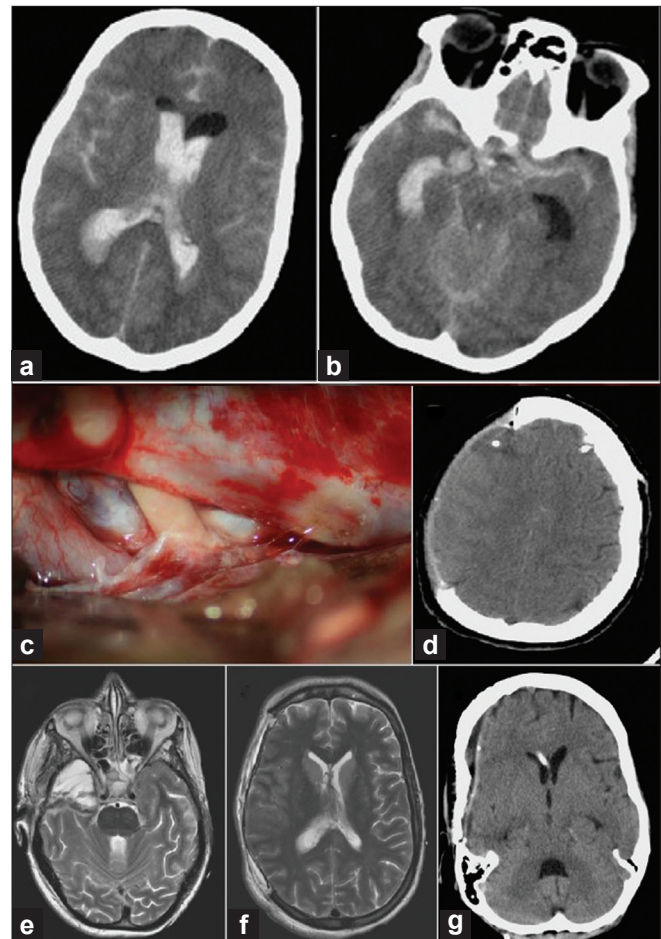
(a–b) Axial CT images demonstrating acute SAH and IVH from a right PCoA aneurysm. (c) Intraoperative view demonstrating the internal carotid artery and cranial nerve III after mesial temporal lobe resection. The right internal carotid artery is located inferomedially. (d and e) Early postoperative axial MR images showing the wide hemicraniectomy without evidence of significant cerebral injury or edema. Note the nondominant temporal lobectomy. (f and g) Late postoperative axial CT images following bone flap replacement and ventriculoperitoneal shunt
